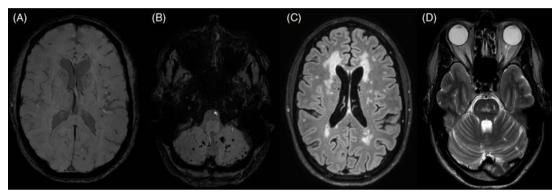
Axial SWI images (A and B) demonstrate predominantly cerebellar microbleeds in patient 2. Axial T2/FLAIR shows confluent periventricular (C) and central pontine (D) white matter hyperintensities.
